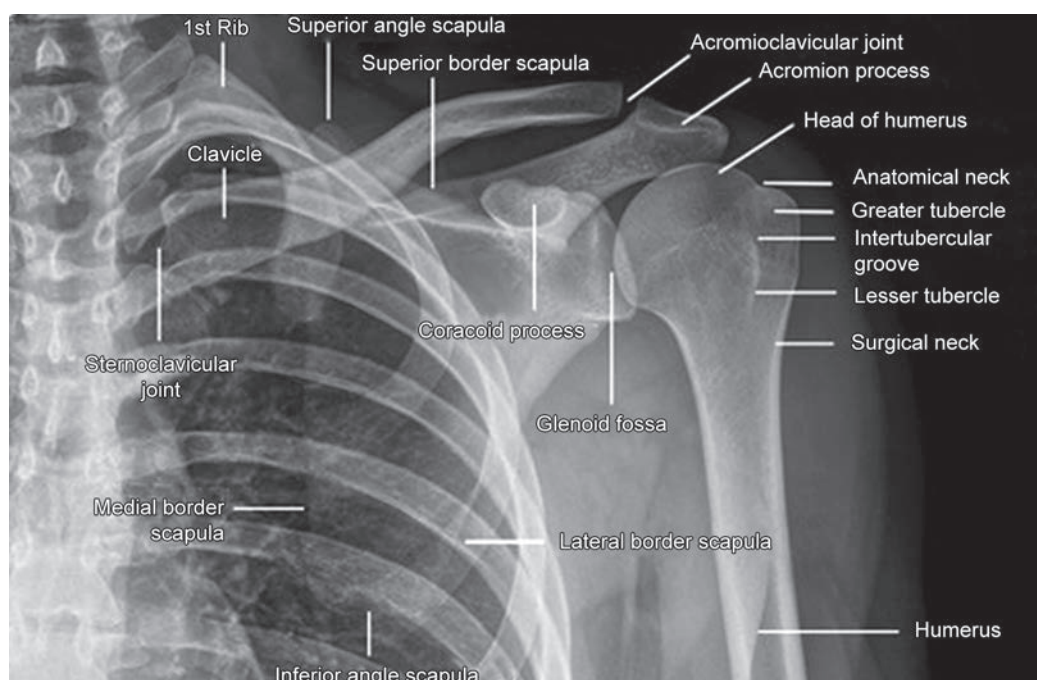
X-ray showing skeletal land marks
